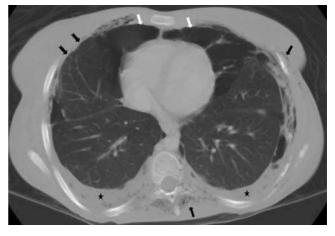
Chest CT scan demonstrates complex loculated anterior mediastinal pneumothorax (*white arrows*), soft tissue emphysema (*black arrows*) and fine subpleural septal thickening (*notched black arrows*) and pleural thickening and effusions (*stars*)
